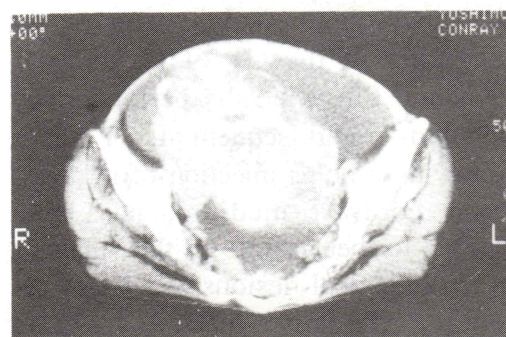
Case 1. CT image in 75-year-old woman with suspected recurrent ovarian cancer.
